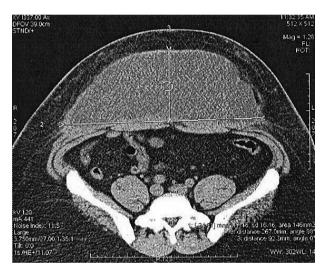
Multi-slice computed tomography of the abdomen, axial plane: liquid collection between fascia and subcutaneous fat tissue of the abdominal wall (lines).
